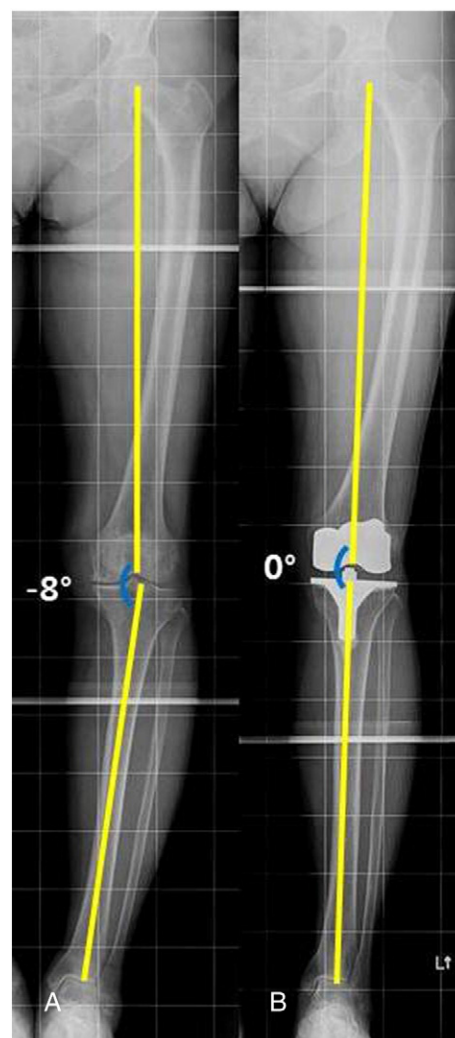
Radiograph showing method used for measurement of coronal alignment (mechanical axis) on a long leg standing radiograph, pre-operative (A) and post-operative (B).
